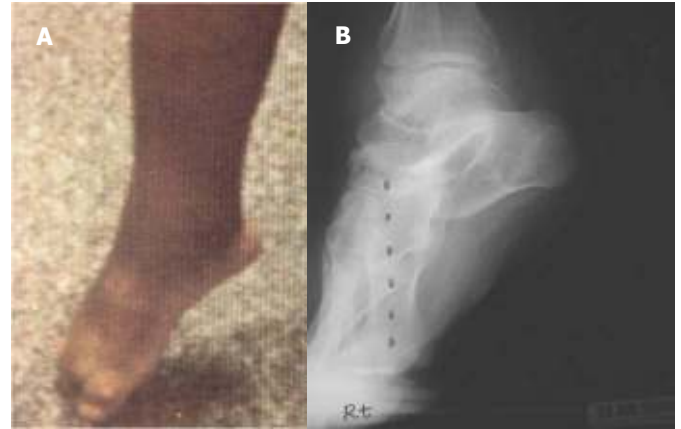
and 1B Preoperative photo (A) and radiograph (B) showing ankle equinus deformity.
